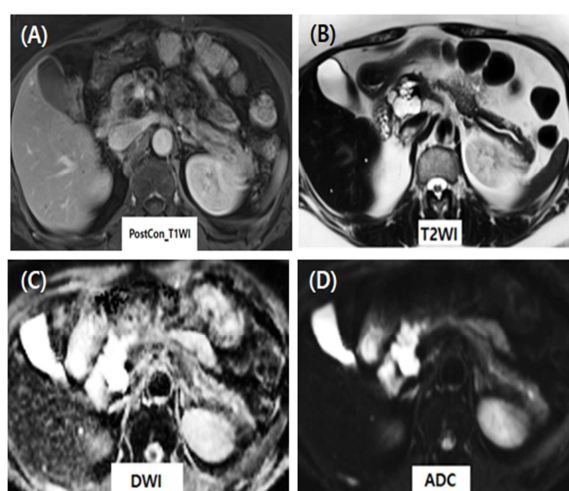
MRI of a 67-year-old woman. (A) T1-weighted contrast-enhanced image, (B) T2-weighted image, (C) Diffusion weighted image, (D) Apparent Diffusion Coefficient image
